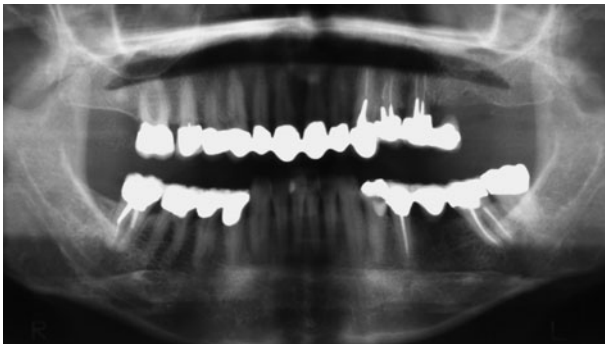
The extent of the external oblique line and the inferior dental nerve trajectory are visible on the panoramic X-ray.
